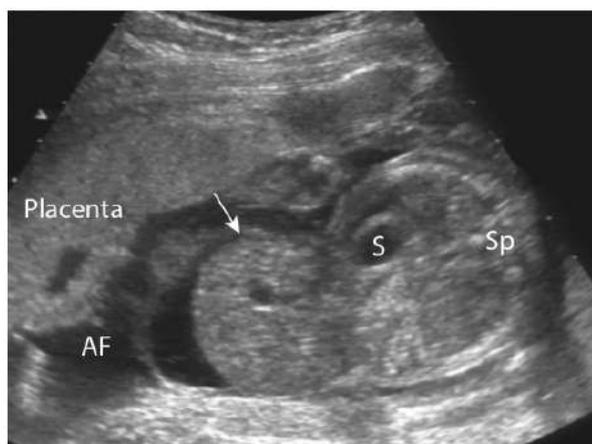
Ultrasound image of exomphalos, showing the sac containing the herniated bowel (white arrow). AF, amniotic fluid; S, fetal stomach; Sp, fetal spine.
